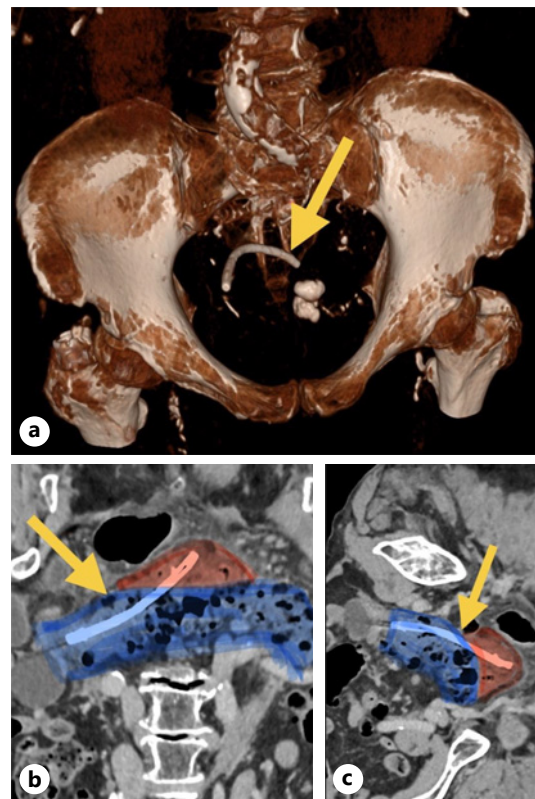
CT (reconstructions) showing stent location in the sigmoid colon in the pelvis (a), sigmoid lumen (blue) and stent location outside the lumen with mesenteric fat stranding (red) (b, c).
